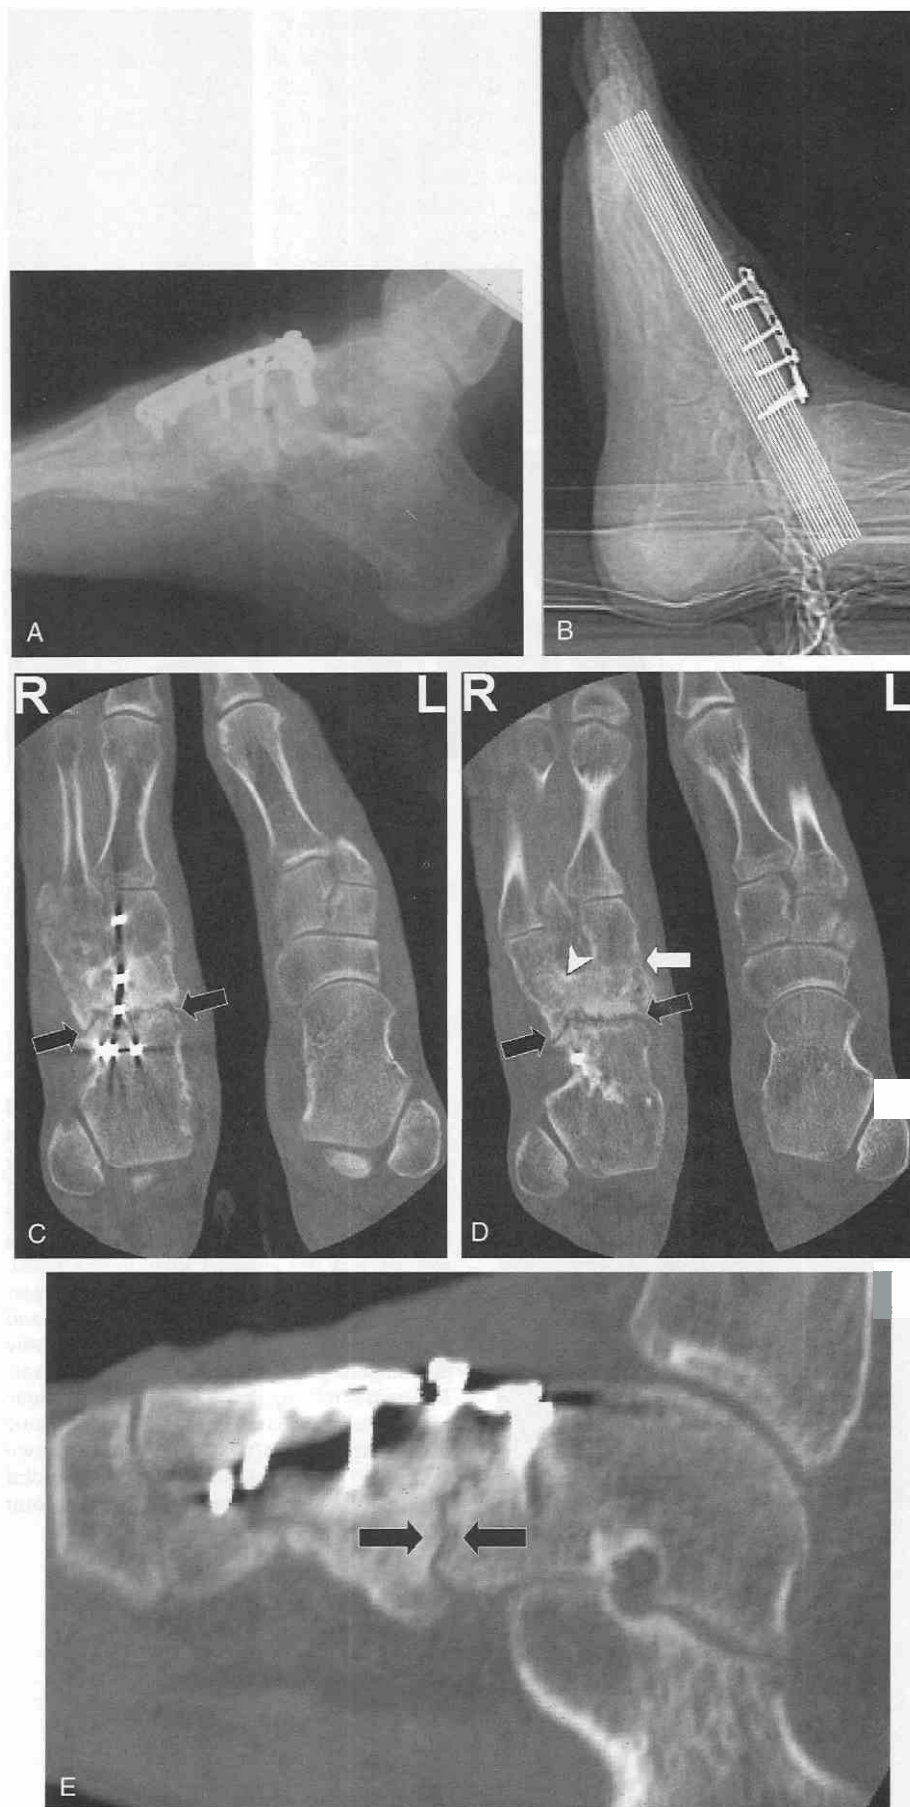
Attempted midfoot fusion in a 26-year-old man. *A*, Lateral radiograph demonstrates a dorsal plate with six screws extending across the talonavicular and navicular-cuneiform joints. *B*, Lateral scout projection for the CT scan. With the toes pointing up, the top of the gantry was angled away from the patient and the midfoot was scanned in the oblique axial plane (*white lines*). *C*, Oblique axial CT image. Even scanning through six screws, the streak artifact is minimal. No cortical bridging is seen across the talonavicular joint (*black arrows*). *D*, Oblique axial CT image, a few slices distal to *C*. At this level, the nonunion of the talonavicular joint is clearly demonstrated (*black arrows*). However, there is solid osseous fusion across the medial navicular cuneiform joint (*white arrow*) and partial fusion across the lateral navicular cuneiform joint (*arrowhead*). *E*, Sagittal reformatted CT image confirms the nonunion of the talonavicular joint (*black arrows*).
